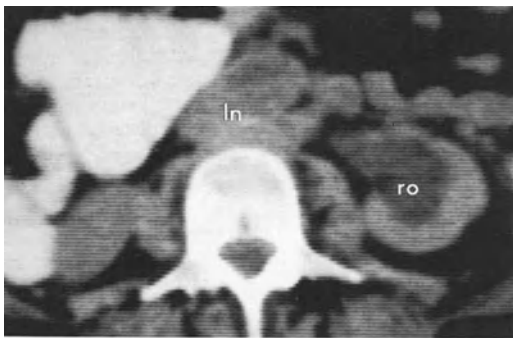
CT: dilation of pelvis of left kidney because of obstruction of ureter by lymph nodes. In this section enlarged para-aortic lymph nodes (*ln*) are visible. *ro*, renal obstruction
